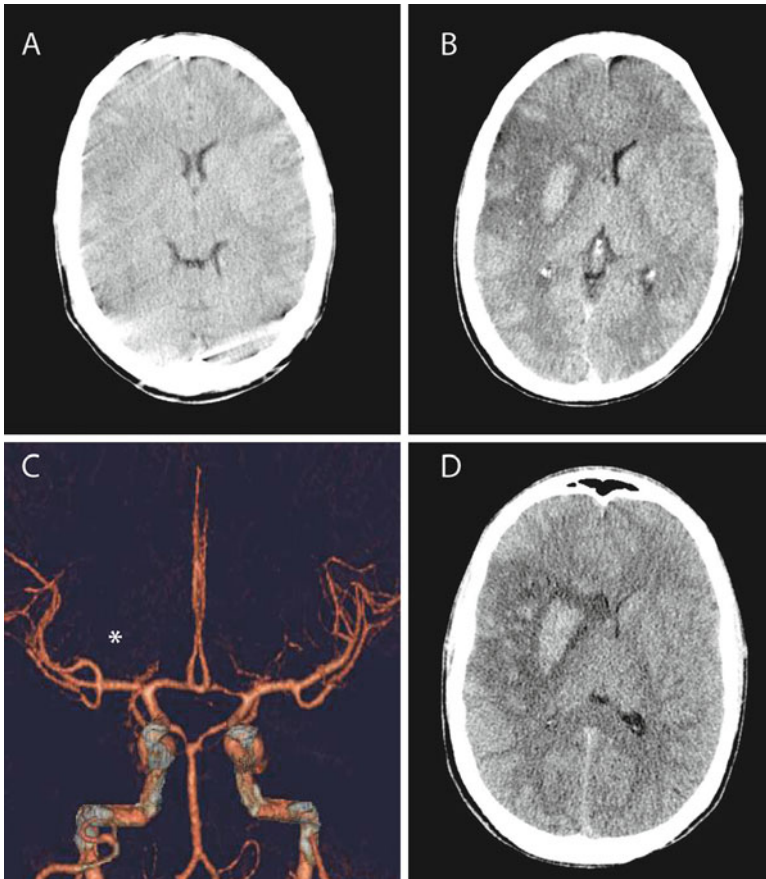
Intravenous recombinant tissue plasminogen activator (rtPA) for acute ischemic stroke. This 58-year-old man presented to the emergency department 3.5 h after the acute onset left hemiplegia. (a) Initial computed tomography (CT) scan was interpreted as having no hemorrhage and evidence of early right middle cerebral artery (MCA) distribution ischemic changes. Intravenous rtPA was administered without neurologic improvement. (b) Eight hours after administration of rtPA the patient had a decreased level of consciousness and underwent repeat CT scan demonstrating early hemorrhage in the putamen ipsilateral to the stroke. (c) CT angiography obtained at that revealed a patent right M2 branch with absent flow in the lenticulostriate arteries on the right side (*asterisk*). (d) Twenty-four hours after presentation, a plain CT was obtained that demonstrated extension of hemorrhage and increased stroke and peri-hematoma edema resulting in midline shift
